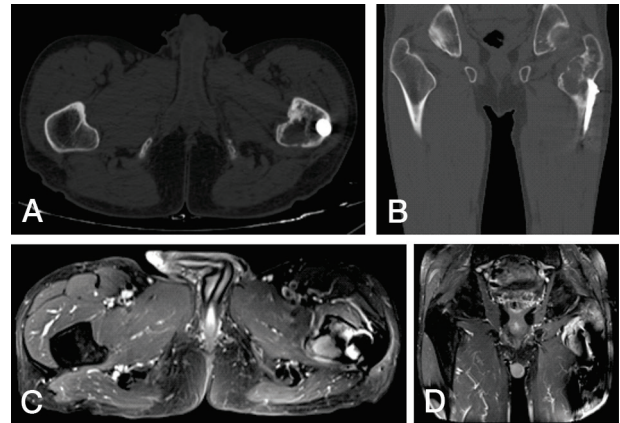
Axial (A) and coronal (B) computerized tomography of the thigh shows a lytic lesion originating from the left lesser tubercle. Axial (C) and coronal (D) magnetic resonance imaging of the thigh also shows a mass arising from the left lesser tubercle that extends adjacent soft tissue
